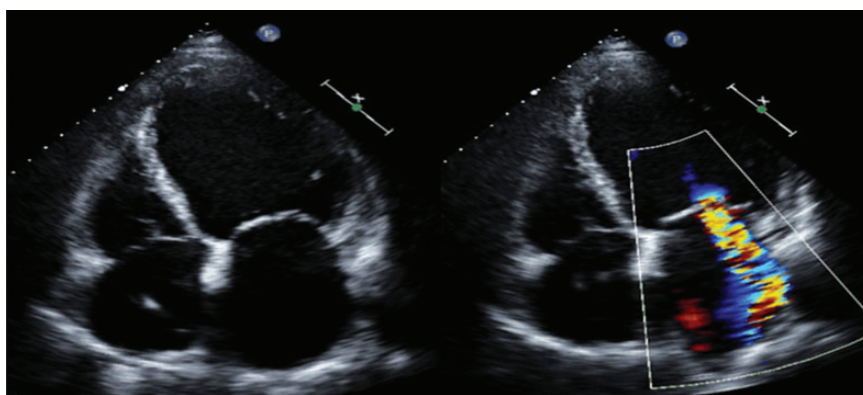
Typical 2D transthoracic echo image of a patient with functional MR (left). Note the dilated left ventricle, and the displacement of the mitral leaflets into the left ventricle. This results in significant MR (right).
